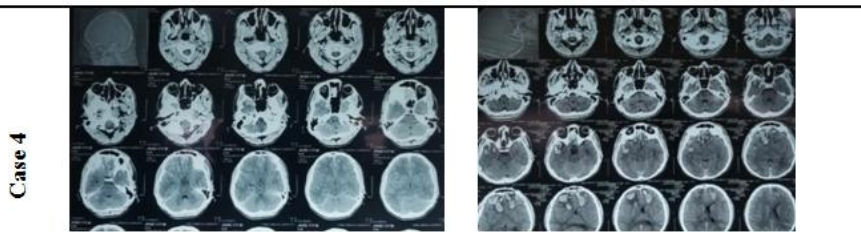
CT scan of head on admission Figure 6b: CT scan of head after 48 hours
